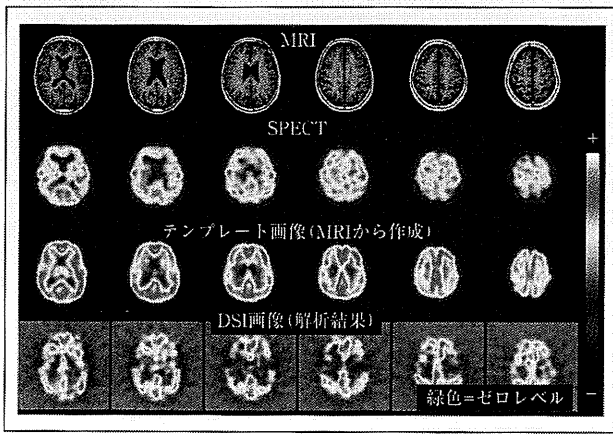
FUSEによるアルツハイマー病患者のSPECT画像の処理結果
